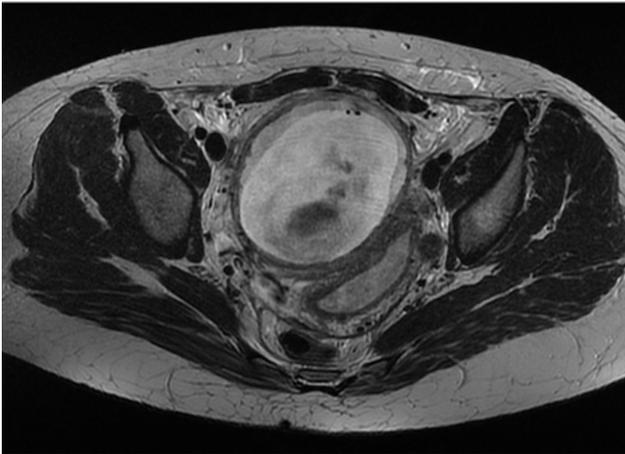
Transversal MRI cut showing the existence of a left unicornuate uterus with a gestating right rudimentary horn with a thin myometrium and signs of placental accretism.
